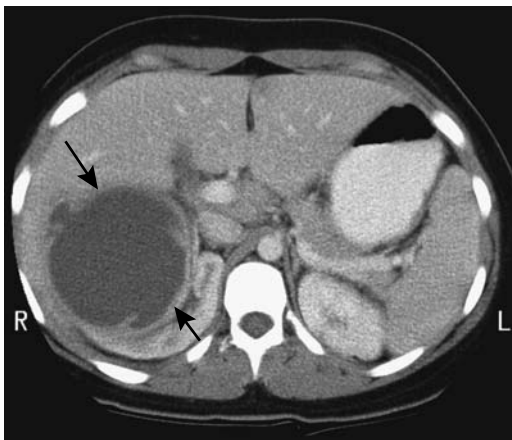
Right renal abscess. Contrast-enhanced CT reveals a huge fluid-filled structure at the superior pole of the right kidney (arrows). It was drained percutaneously. (Courtesy of Patrick Fultz, M.D., University of Rochester.)
